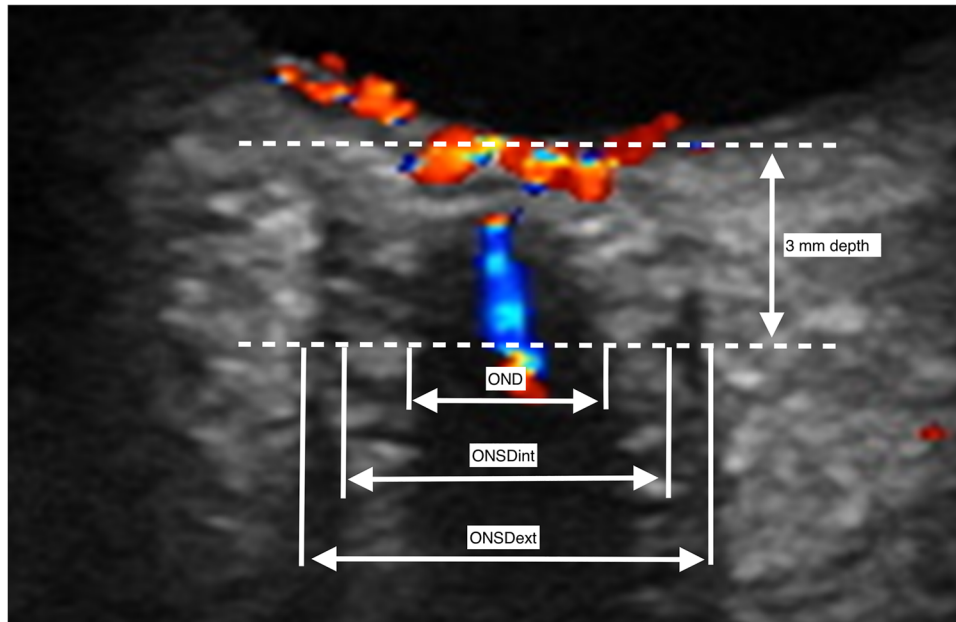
Color doppler of retinal artery. Image of ONSD with color doppler of the retinal artery and vein as an aide to identify the nerve and its direction properly. Red represents blood flow upward in the image (artery) and blue represents blood flow downward in the image (vein). Image from Pansell et al.,<sup>11</sup> reproduced under the Creative Commons License (CC BY-NC 4.0)
